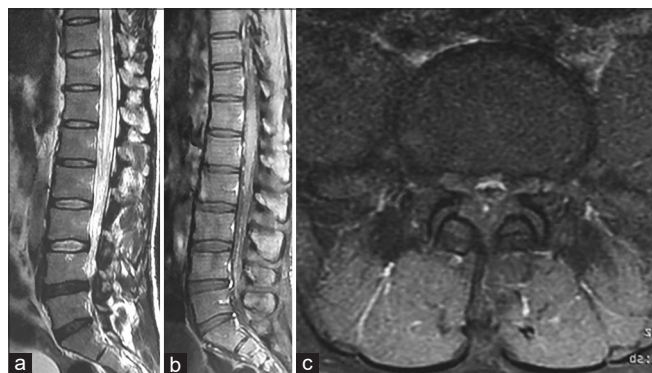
Sagittal (a) T2-weighted, axial (b) and sagittal (c) postcontrast T1-weighted spinal magnetic resonance imaging, showing a high signal intense lesion in the conus medullaris, with increased flow voids over the spinal cord with more evident venous tortuosity and dilated vessels in the subarachnoid space
